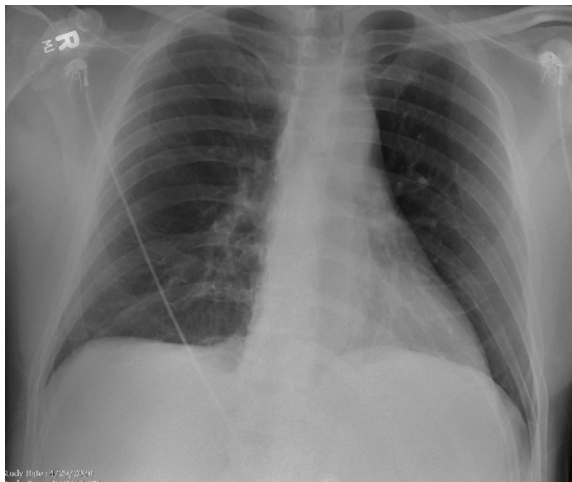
Chest X-ray showed possible right small pleural effusion.
